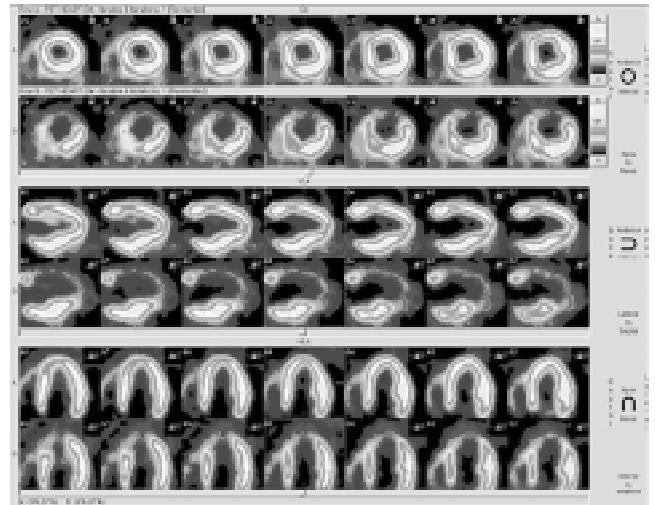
Comparison of left ventricle myocardial activity before and after the stem cell application in a patient overcoming a myocardial infarction. A marked reduction of the extent of the necrosis apically and anteroseptally is apparent following the stem cell application. Bottom row of individual projections: FDG-PET prior to stem cell application. A lack of activity recorded anteroseptally and apically. Top row of individual projections: increased uptake in the affected myocardial regions following the stem cell application.
